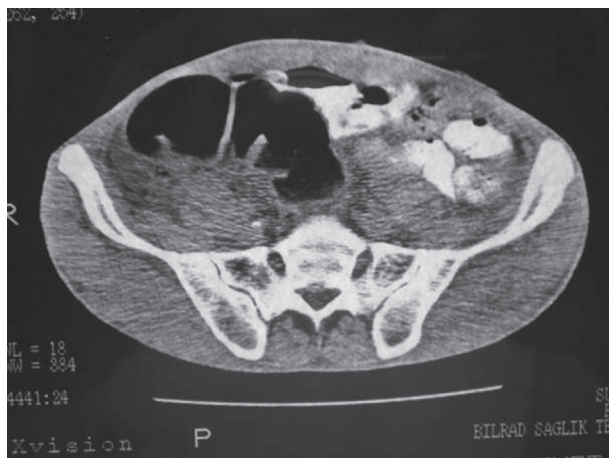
Transverse CT scan showing the abdominal mass and dilated intestinal loops
